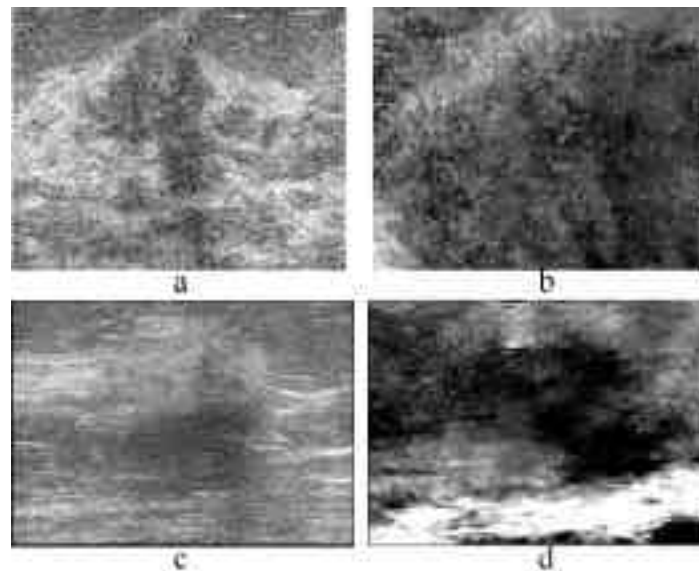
Top row; sonogram (a) and elastogram (b) of a 12 mm lesion diagnosed as stromal fibrosis (52 yrs old patient). Bottom row; sonogram (c) and elastogram (d) of a 16 mm lesion diagnosed as invasive lobular carcinoma (66 yrs old patient).
